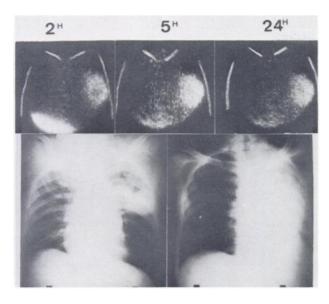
Patient TOM with primary left lung cancer. Uptake of 67 Cu (1 mCi of 67 Cu-citrate) is intense as early as second hour after injection. At time of examination, pleural effusion prevented us from seeing limits of tumor on lung x-rays (right x-rays). Left x-rays were taken few weeks before examination.
